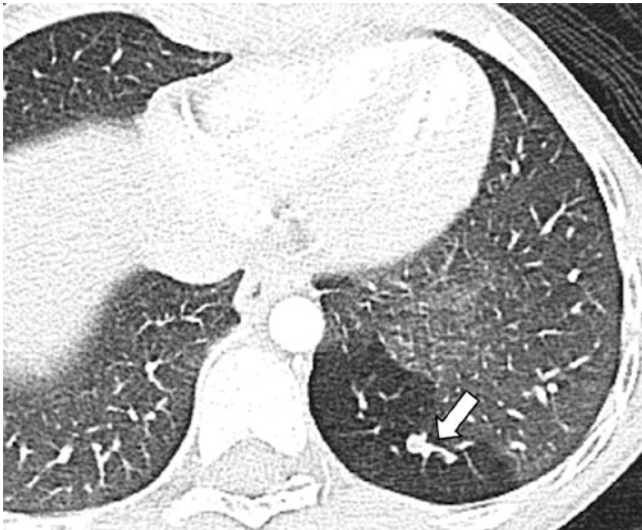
An 8-year-old girl with an incidental detection of bronchial atresia. Axial lung window CT image shows an oval-shaped opacity (arrow) located in the left lower lobe with adjacent surrounding air trapping
